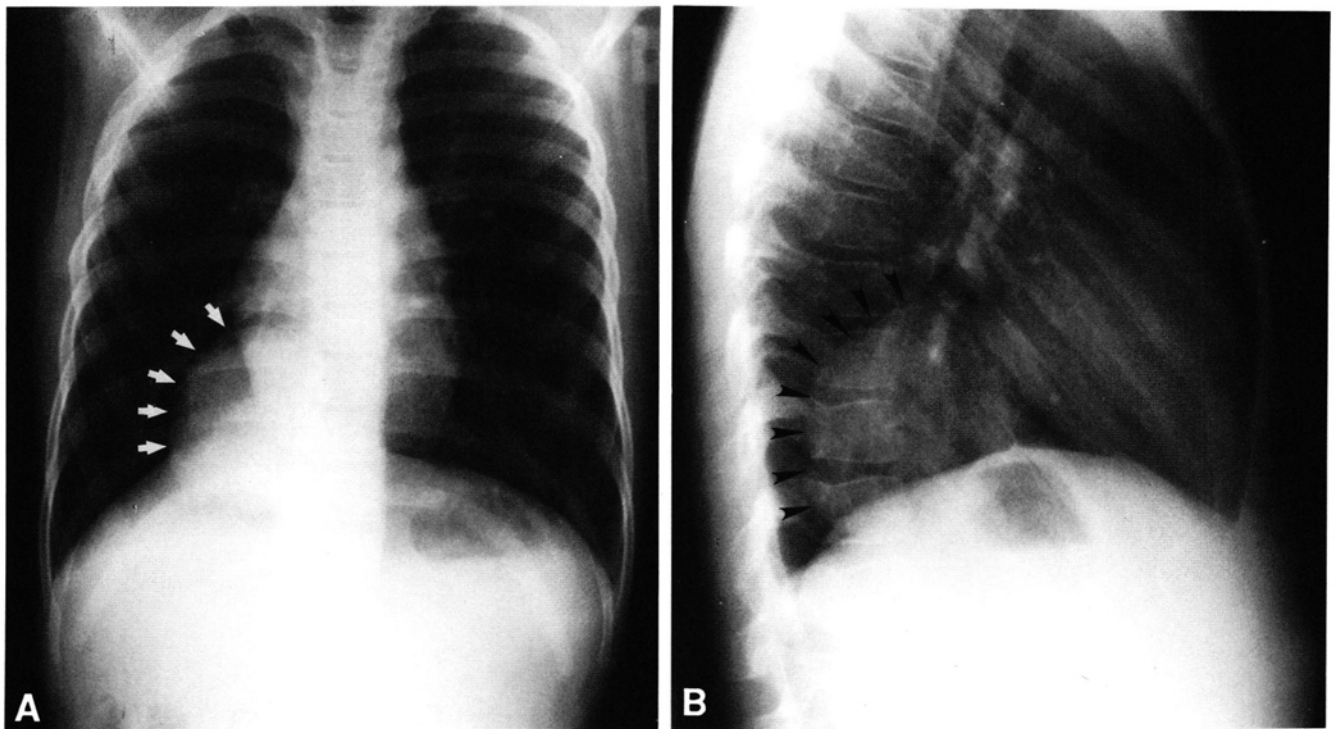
(A) PA chest x-ray showing a mass (white arrows) in the medial aspect of the right lower chest and (B) right lateral view demonstrating a large posterior mediastinal mass (black arrow).
